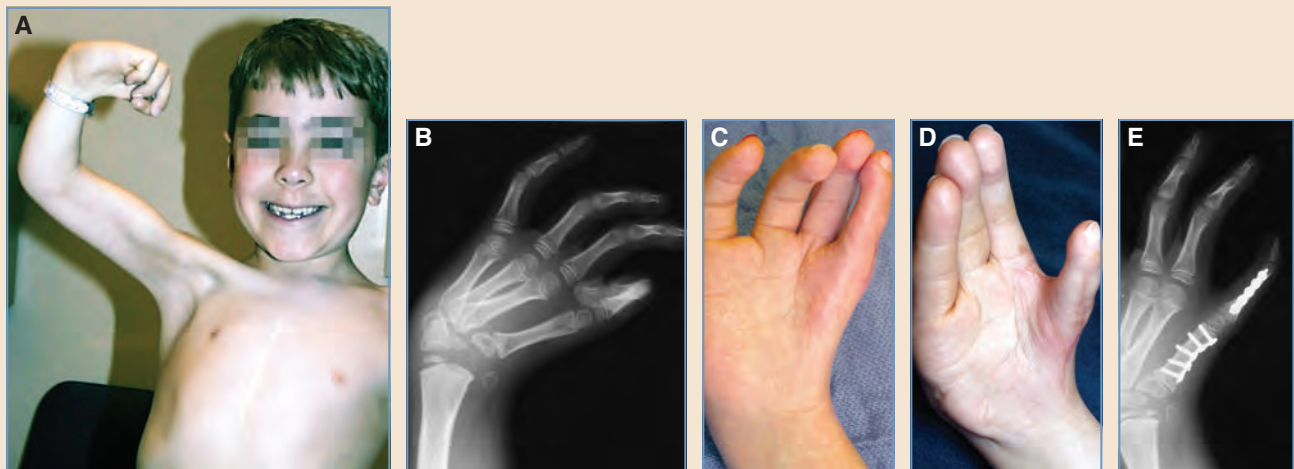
Rotation-recession osteotomy versus pollicization. A, This proud 7-year-old flexes his pectoralis major muscle transfer for elbow flexion. The hand and carpus had been centralized earlier, and his hand function was notable for good flexion and extension of the ring and fifth digits and, to a lesser extent, the long finger. The immobile index finger was scissored beneath the long finger with a 90-degree fixed flexion contracture of the PIP joint. B, This radiograph shows the characteristic widening of the distal ulna, which now looks like a radius several years after centralization. The index ray has good skeletal parts in a nonfunctional position. C, Following partial excision and arthrodesis in extension, the index finger was used as a post for the long finger. D, The incision for a rotation-recession osteotomy at the metacarpal level used the Y-V principle. E, The digit was shortened 8.0 mm and abducted to create a wider first web space.
